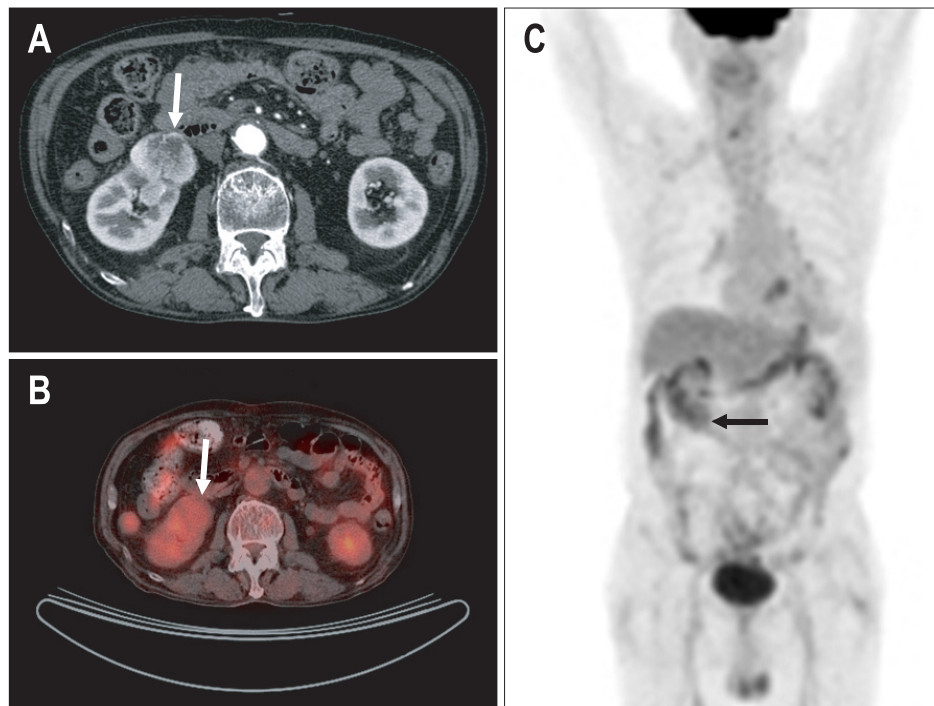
(A) Computed tomography showing a hypervascular mass (arrow) approximately 5 cm long and bilobular in shape in the right kidney. (B, C) Positron emission tomography showing an isometabolic mass (arrow, maxSUV 2.7) in the right kidney. maxSUV, maximum standardized uptake value.
